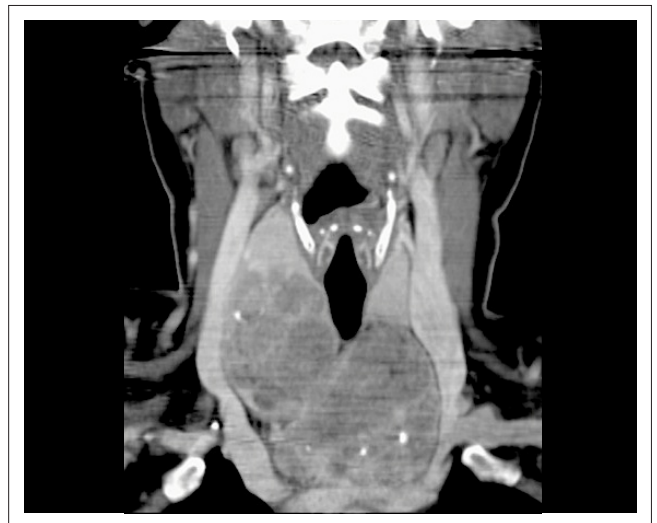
Coronal CT scan image of anterior neck triangles.
